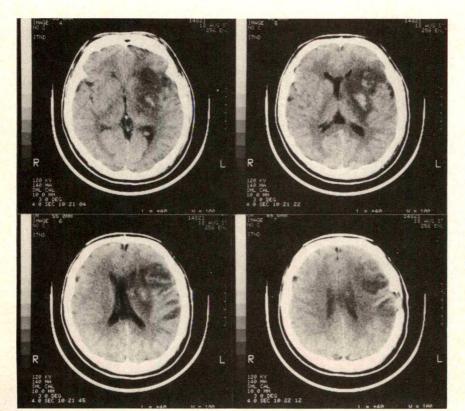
(Ohtsuka and associates). Computed tomography shows low-density areas lying near the sylvian fissure (inferofrontal, supramarginal, angular, superotemporal, and midtemporal gyri) and the putamen.
